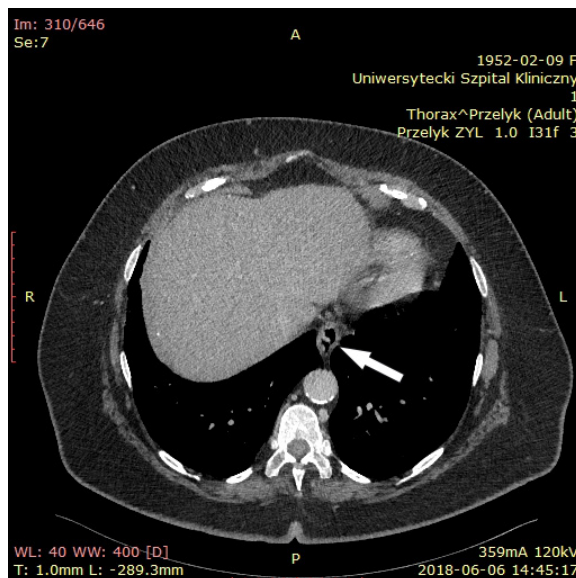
The hydro-CT image in the axial projection shows the exophytic form of gastric cancer in stage T1 localized in the gastric cardia (arrow)
